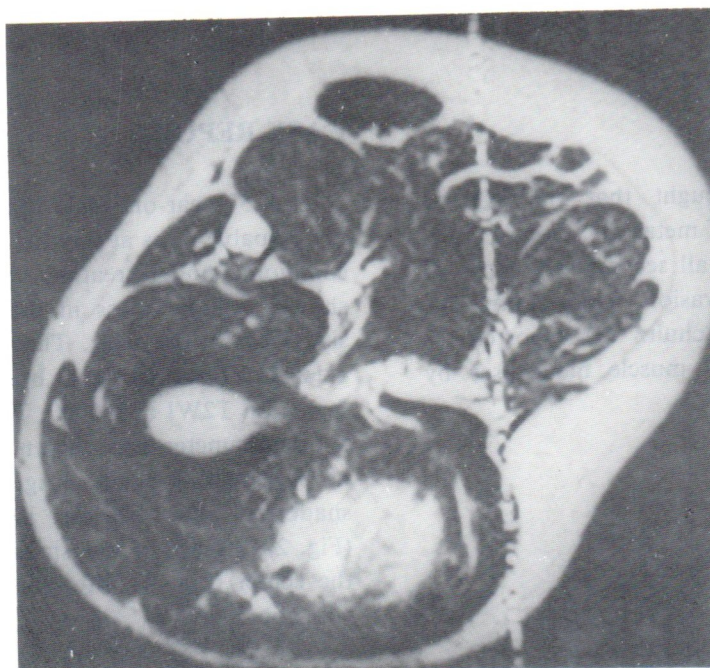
T2WI-axial MRI study (TR 300, TE 80) of the nodule shows homogeneously bright nodule with a small brighter area at the anterior portion, represent necrosis.
